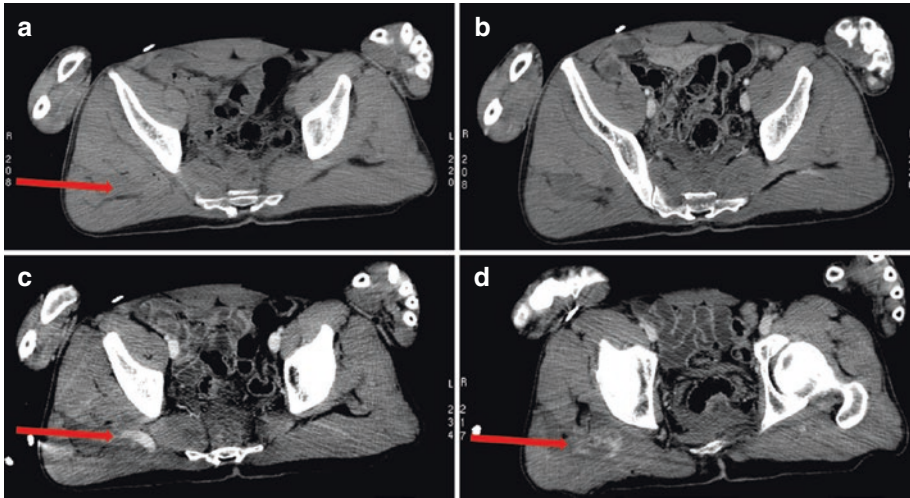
Venous bleeding; axial CT image of the pelvis without c.m. (a) and with c.m. on arterial (b), venous (c), and capillary late (d) phases. Extrapelvic hematoma seen as an iso-hypoattenuating area in the right gluteal region
